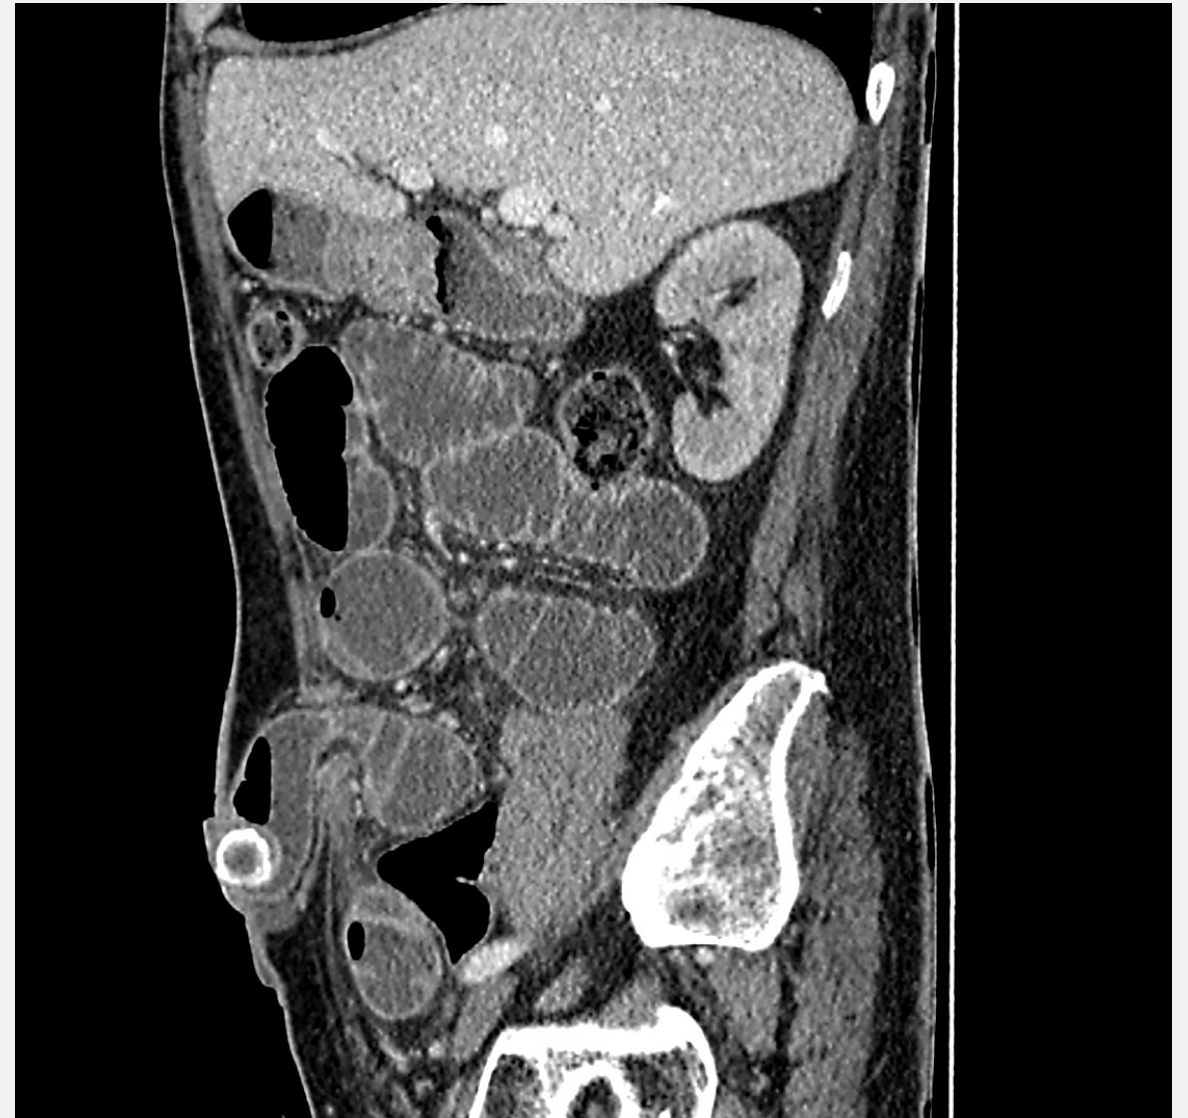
CT in sagittal plane showing site of gallstone within ileostomy tract and secondary small bowel obstruction.
